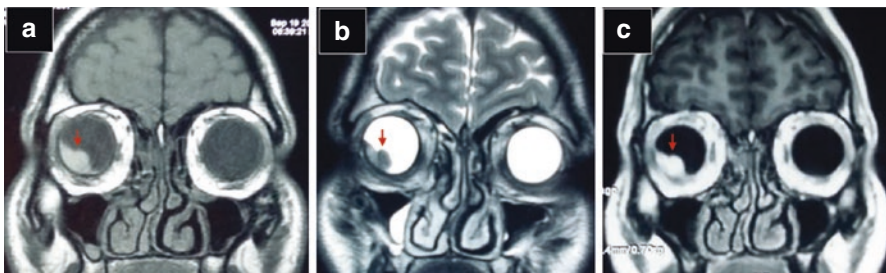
MRI of choroidal melanoma. Mushroom-shaped tumor (arrow) is seen within the vitreous cavity. It is hyperintense in T1 weighted image (a), hypointense in T2 (b) and shows intense contrast enhancement (c)
